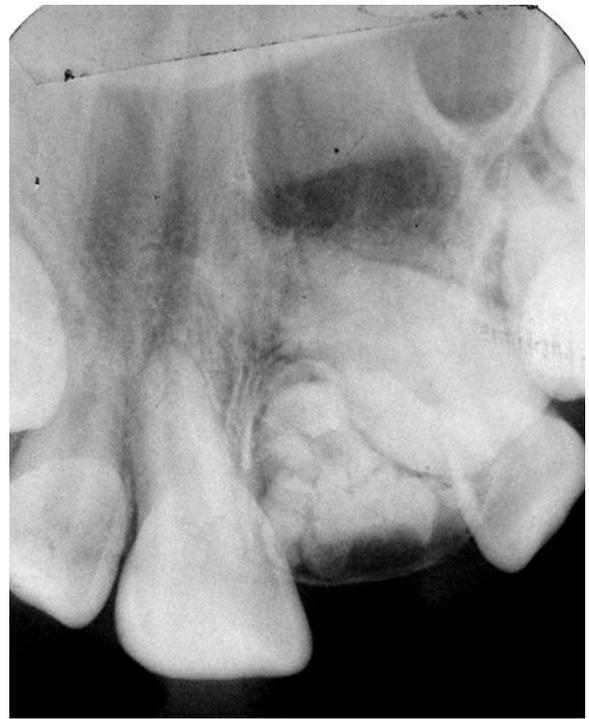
Periapical radiography
